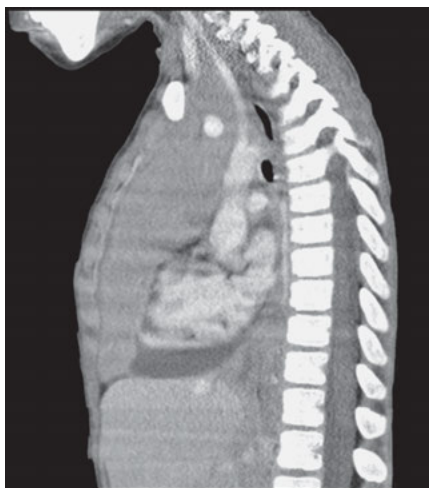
Chest CT of large anterior mediastinal mass obstructing large vessels and associated with pleural and pericardial effusions.
